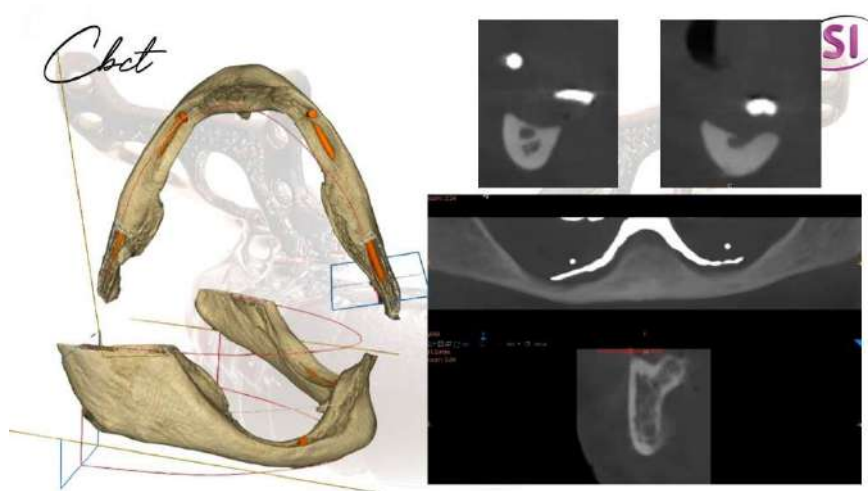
CBCT 3D reconstruction and coronal sections.
